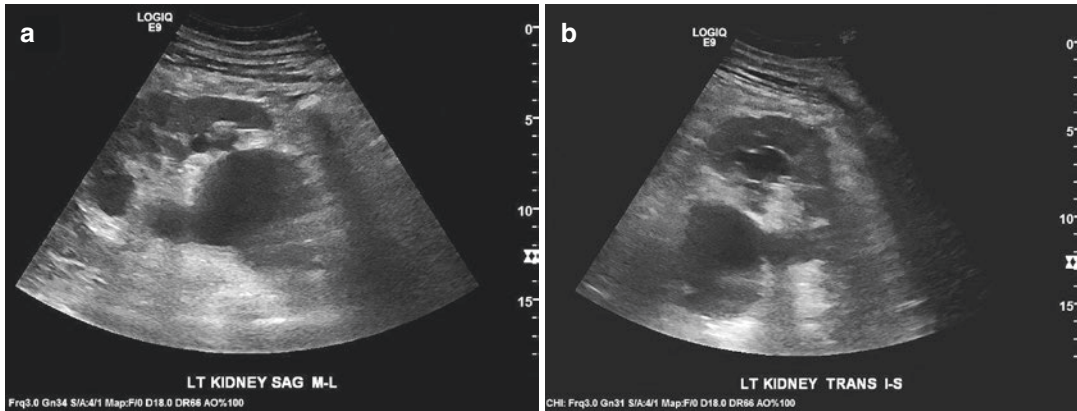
(a, b) Ultrasound images showing massive dilation of the renal pelvis and collecting system (hydronephrosis) due to ureteral obstruction
